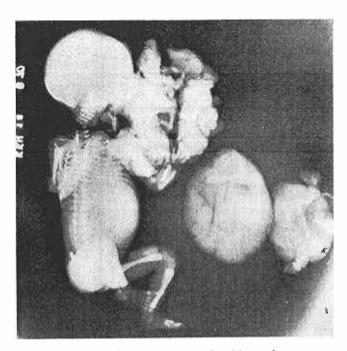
X-ray of the stillbirth showing bizarre bone structure in the giant teratoma and bone formation in one of the primitive limbs.
